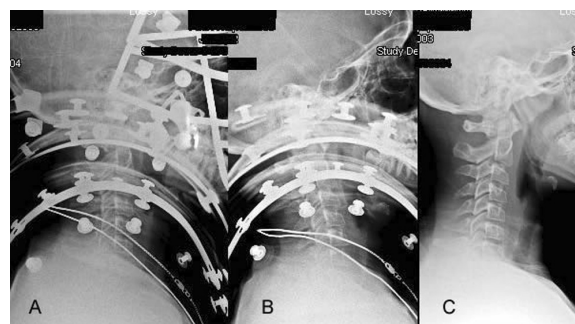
Sample lateral radiographs taken of a 12-year-old child wearing helmet and shoulder pads (A), shoulder pads only (B), and no equipment (C).
